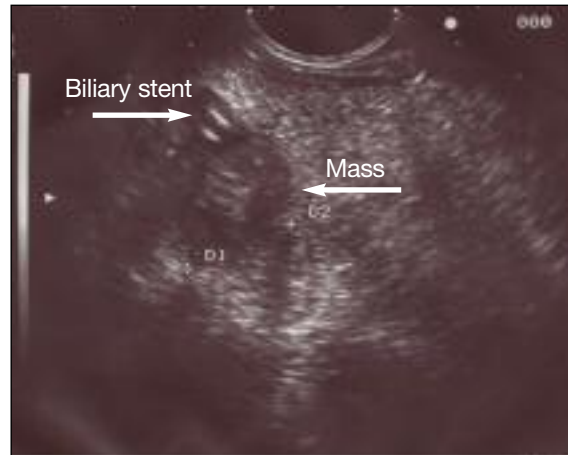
Endoscopic ultrasound image demonstrating pancreatic mass adjacent to a stented common bile duct.
